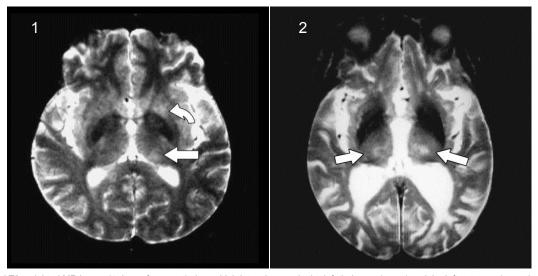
Axial T2-weighted MR image (4 days after onset) shows high intensity area in the left thalamus (arrow) and the left putamen (curved arrow). Figure 2: Axial T2-weighted MR image (8 days after onset) shows high intensity area in the bilateral thalamus (arrow).
